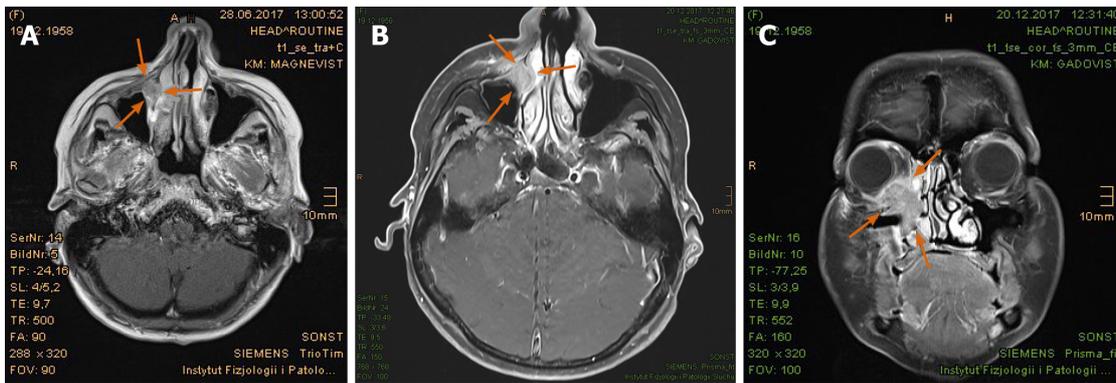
Continuously growing tumor lesion in the right lacrimal sac invading the adjacent orbit and sinonasal spaces, presented as magnetic resonance imaging. A: Initial tumor extent in the antero-medial recess of the right maxillary sinus in June 2017; B: Size progression in December 2017, presented in axial plane; C: Distinct tumor invasion of the right orbit and neighboring sinonasal spaces, presented in coronal plane. Tumor marked with arrows.
